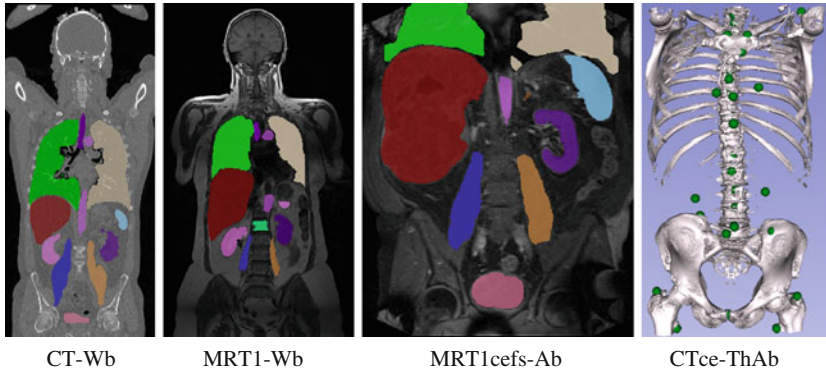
Anatomical structure annotations in CT, MRT1 and a MRT1cefs volume (*a-c*) and visualization of annotated landmarks in a CTce volume (*d*)
